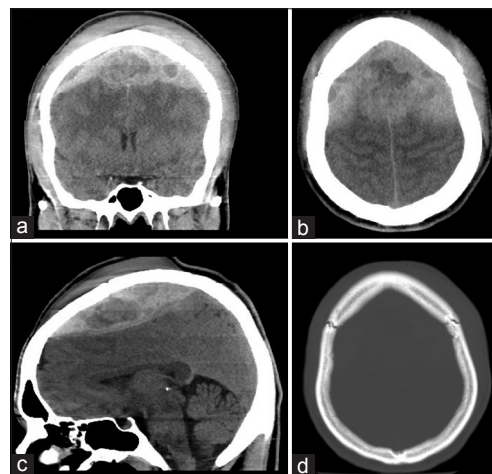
Preoperative noncontrast CT head – (a) coronal cut at the level of the sphenoid sinus, (b) vertex axial cut, (c) mid-sagittal cut, showing a large vertex epidural hematoma with mixed density suggestive of hyperacute hemorrhage, active extravasation and downward herniation. (d) vertex axial cut, bone window, showing coronal suture diastasis
